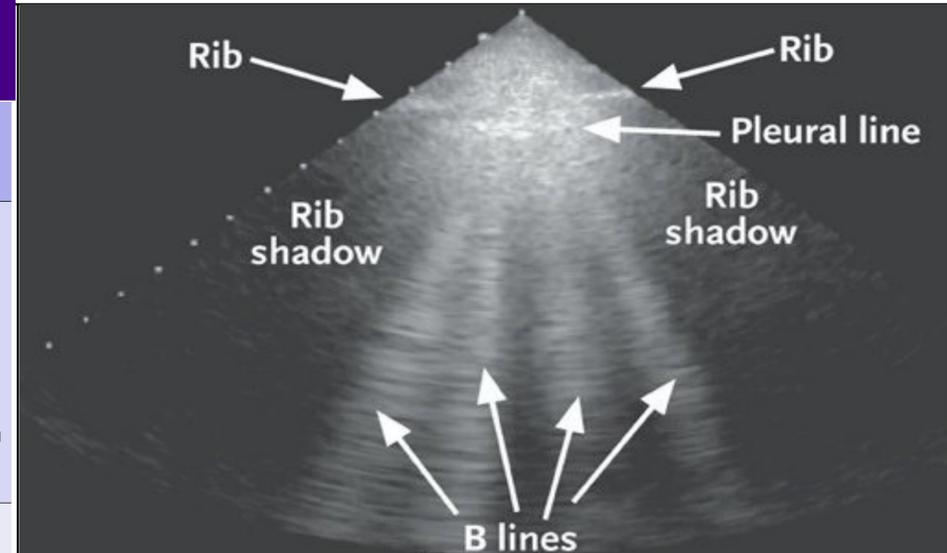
B lines or “comet-tail artifacts” on pulmonary ultrasound
